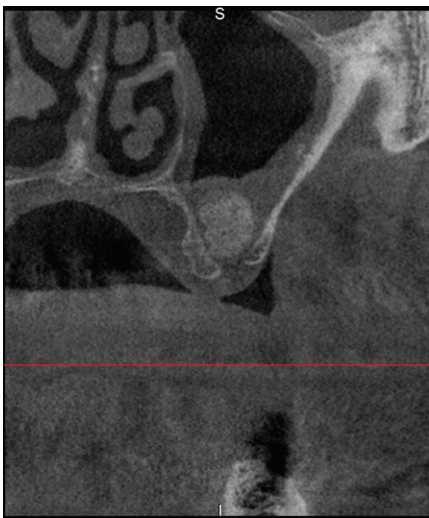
CBCT taken 6 months after surgery, showing no contact between the graft and sinus lateral and medial bone walls. The graft appeared enclosed under a sort of dome deriving from the detachment of the Schneiderian membrane only from the sinus floor, receiving less osteoprogenitor cells and blood supply, and resulting in a slower cellular colonization and new bone formation.
